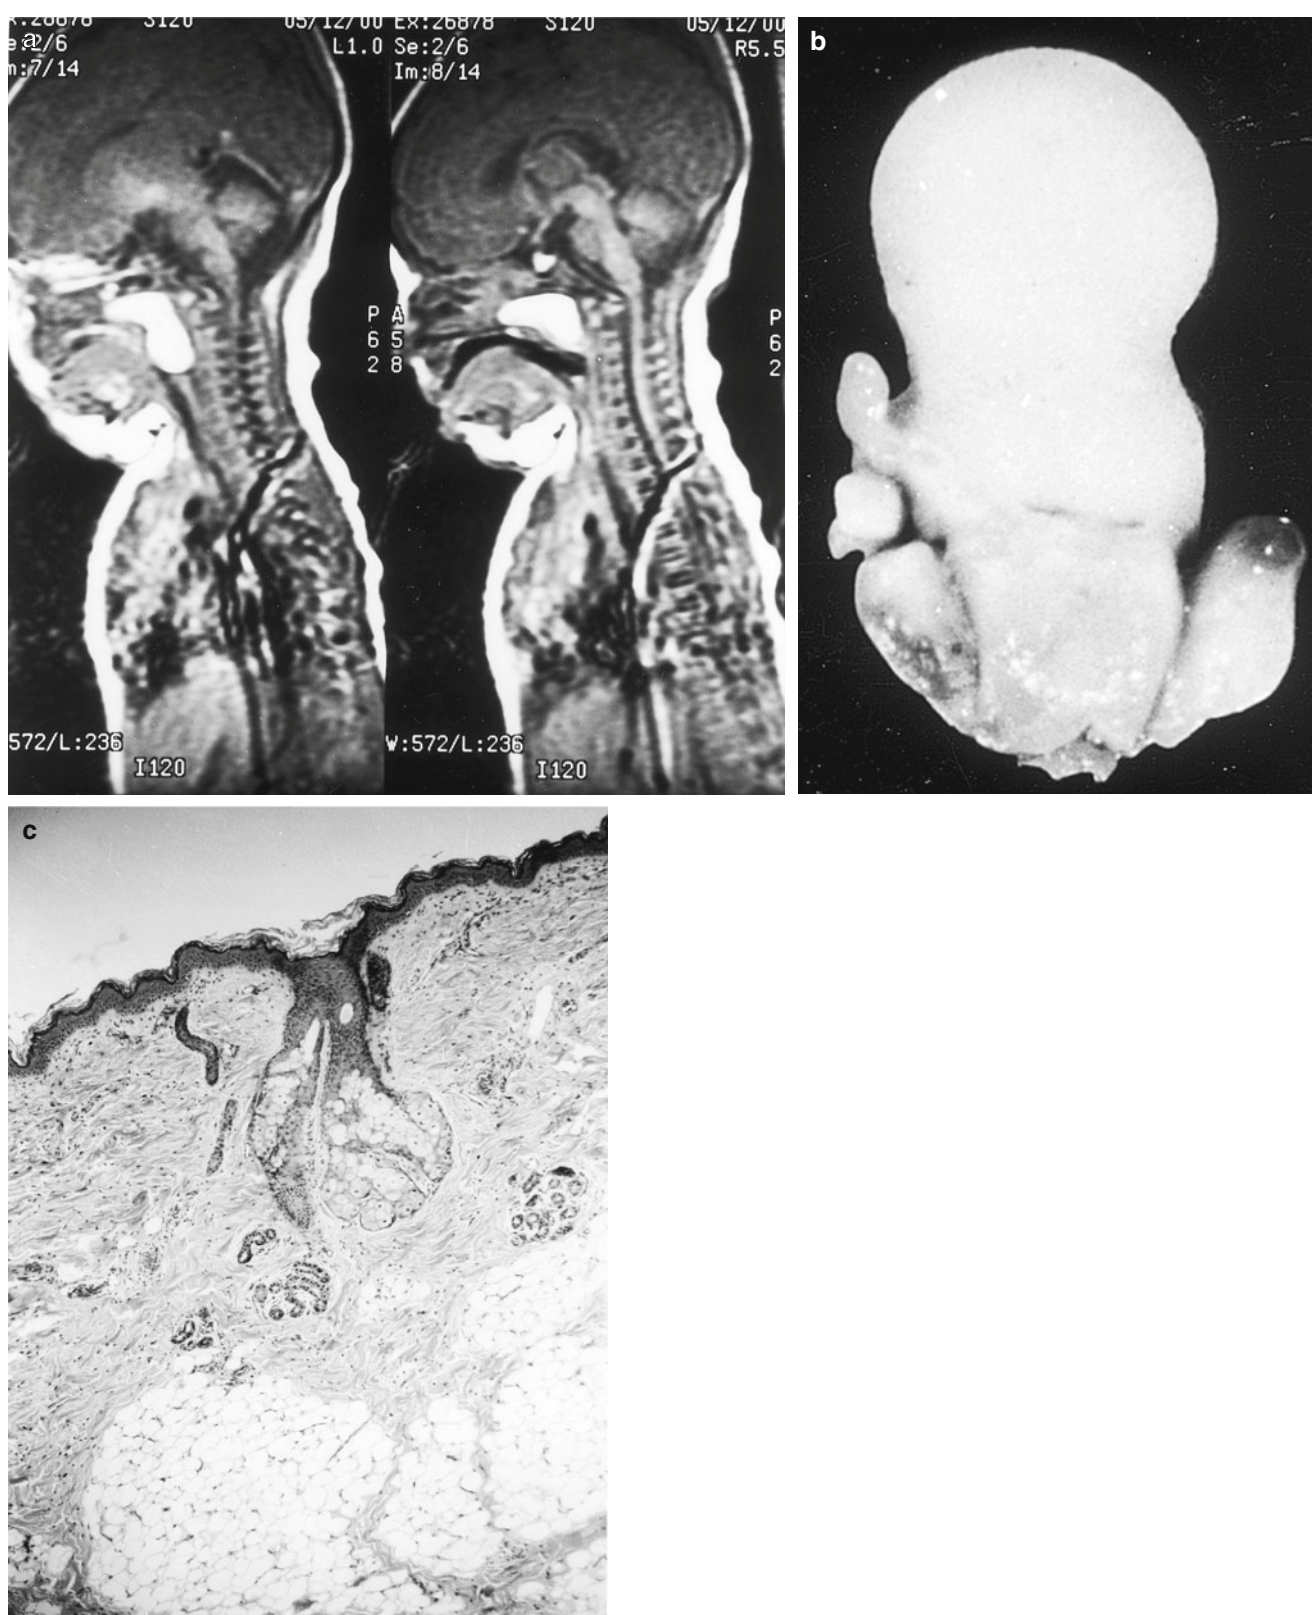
Nasopharyngeal dermoid (“hairy polyp”). Intermittent respiratory distress related to positioning of the infant was noted shortly after birth. Laryngoscopy revealed a fingerlike projection protruding from and obstructing the nasopharynx. (a) Radiograph shows a bright white mass within the nasopharynx and oropharynx with signal
